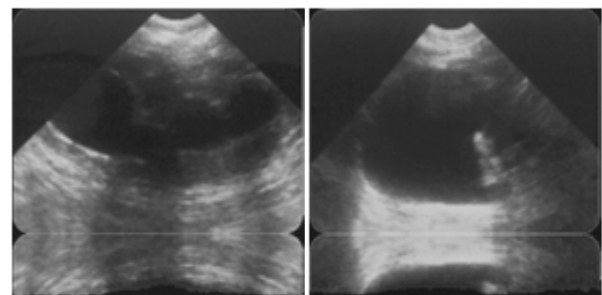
Preoperative right and left renal ultrasonography.
